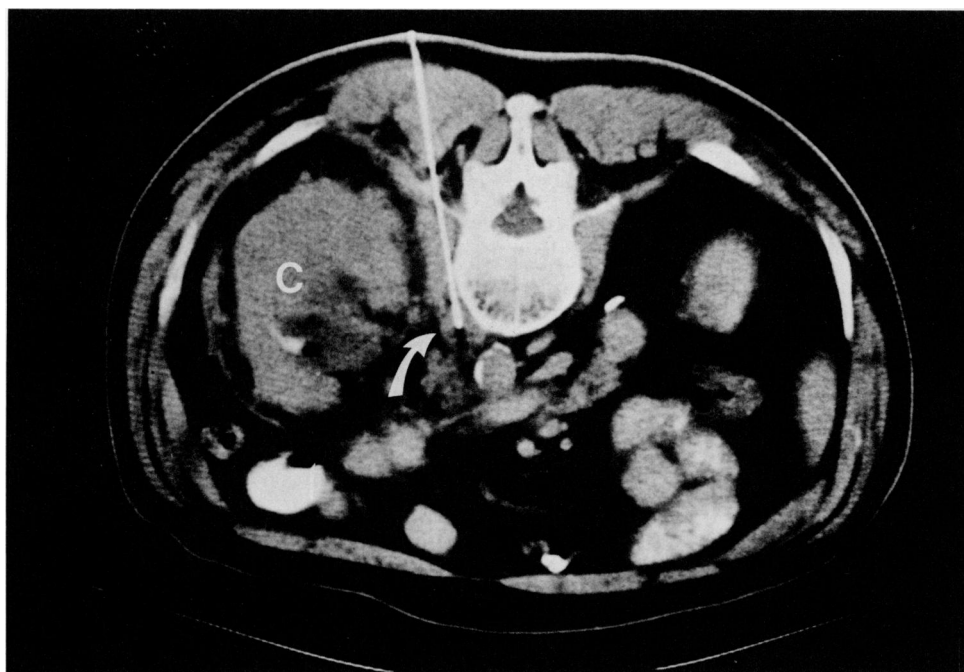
CT scan of patient in prone position to enable needle access to a 1 cm retroperitoneal lymph node (curved white arrow) (non-pathologically enlarged by standard CT size criteria). Biopsy demonstrated metastatic disease in this patient with transitional cell carcinoma (c).
